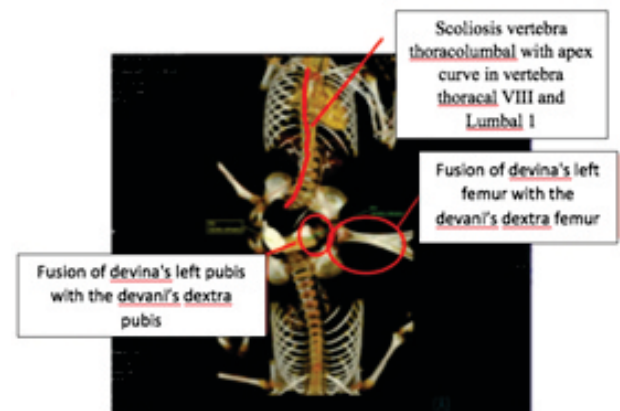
CT Angiography of proximal lower extremities.
